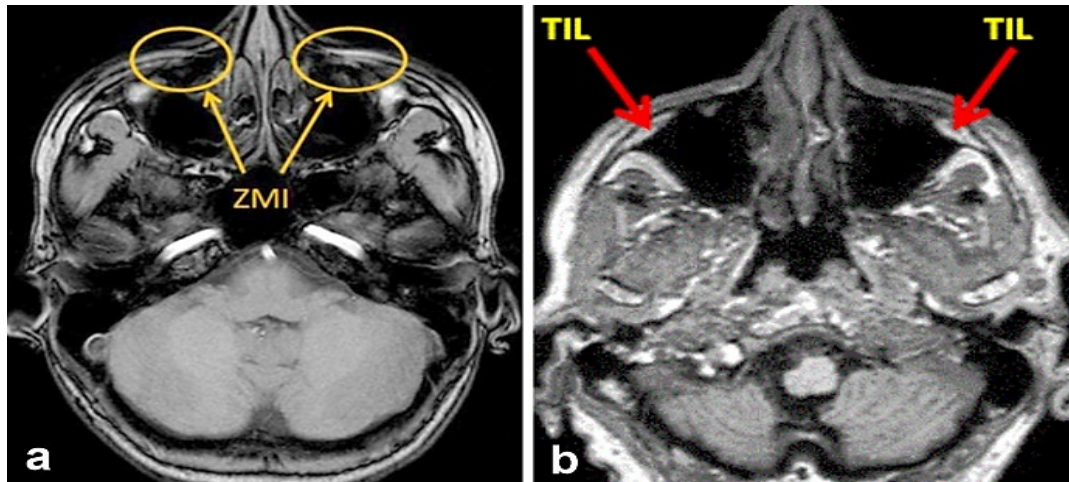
Axial MRI: (a) Infraorbital insertion and transSMAS of the major zygomatic muscle (ZMI); (b) TransSMAS insertion of the levator labii superioris muscle (TIL). MRI: Magnetic resonance imaging.
